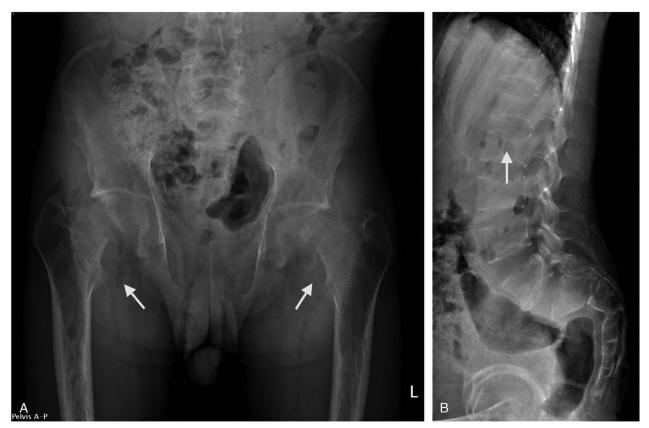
A, Plain radiograph of the pelvis reveals severe osteoporosis, and the shepherd's crook deformity of both proximal femurs is indicative of repeated microfractures. B, Lateral view of the lumbar-sacral spine showing multiple compression fractures of the vertebral bodies.
